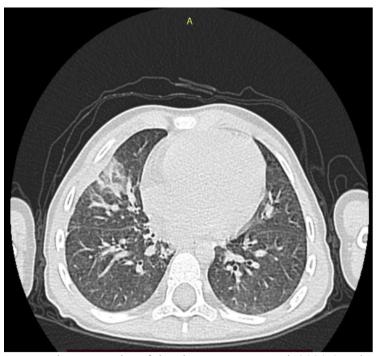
Computed tomography of the chest organs, March 2020 (Voskresensk).
